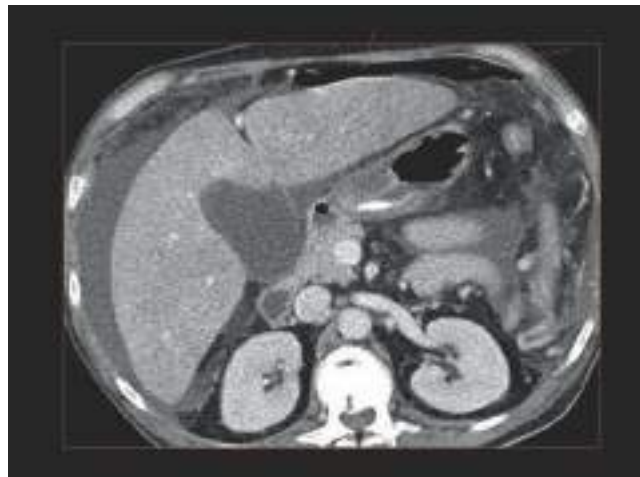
Computed tomography scan of a blunt trauma patient showing free air and free fluid in the absence of solid organ injury. Exploration revealed a cecal injury.
